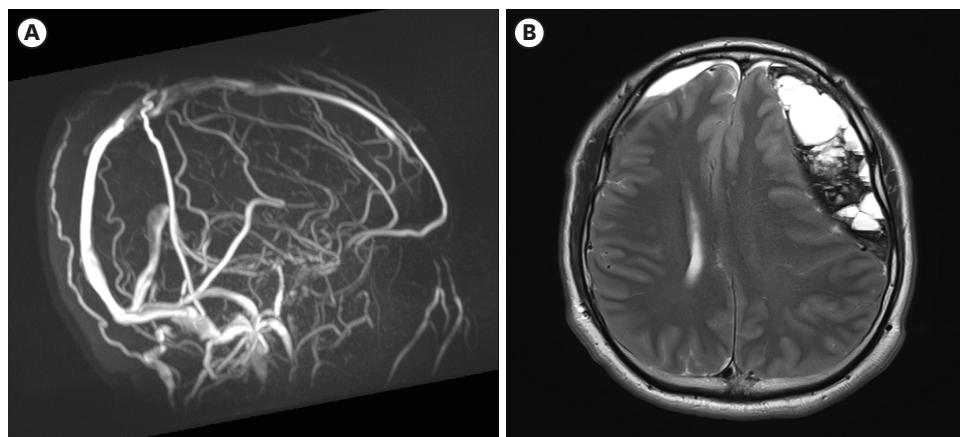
(A) Two months follow-up magnetic resonance imaging scan shows improvement in cerebral venous thrombosis, (B) newly occurred subdural hematoma in the left cerebral hemisphere.
